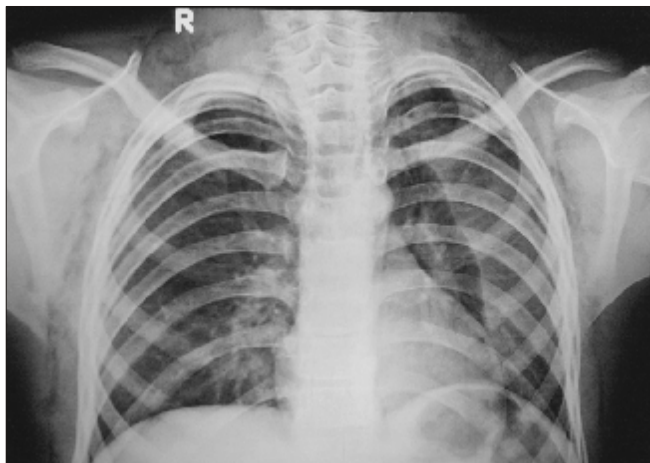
Chest x-ray of a child with asthma showing bilateral subcutaneous emphysema and pneumomediastinum.
